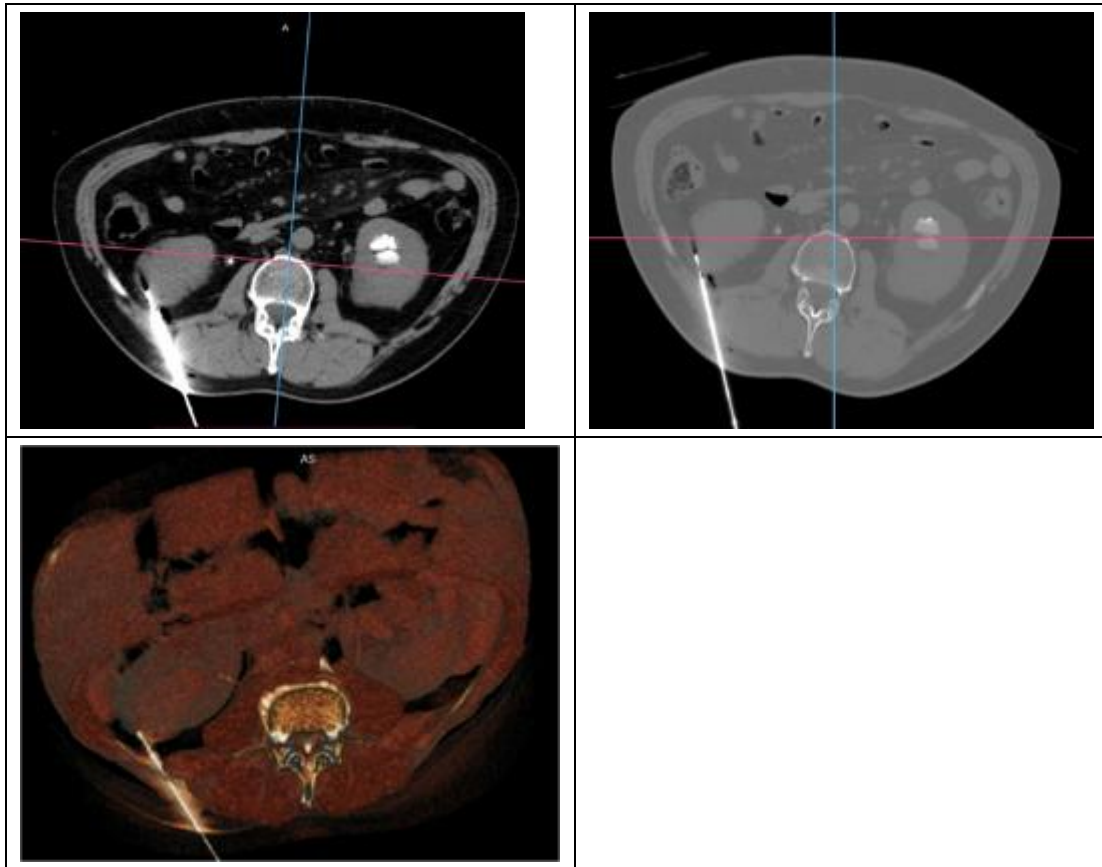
CT scan guided perinephric soft tissue biopsy, under local anesthesia (8 cc Lidocaine 2%), a 20 G x 15 cm, biopsy device was used to obtain tissue samples from the right kidney
